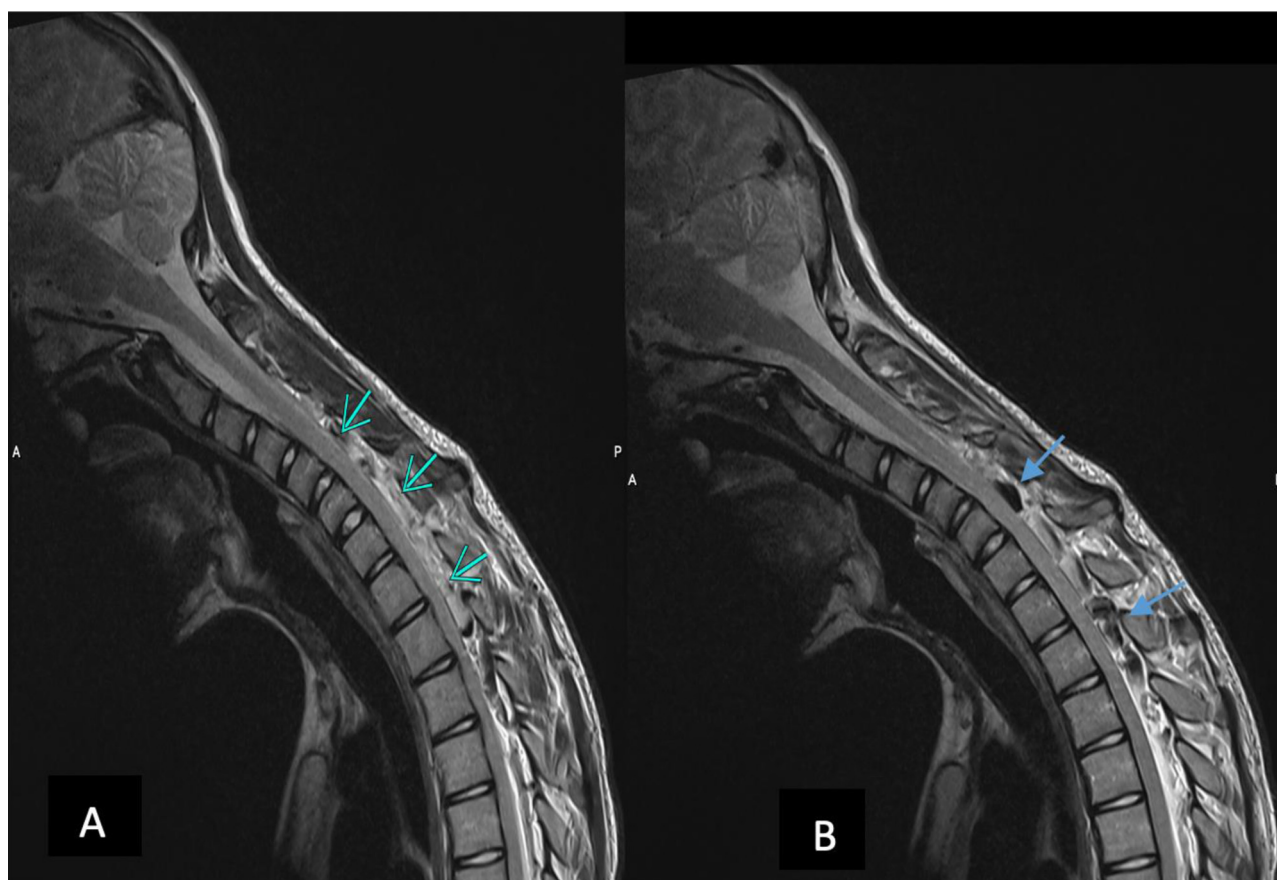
Sagittal T2 weighted flexion cervical MRI. A. Sagittal T2 weighted flexion cervical MRI showing enlarged epidural posterior space. B. Sagittal T2 weighted flexion cervical MRI showing turgescence of epidural veins.
